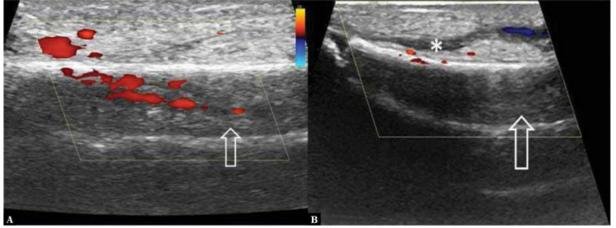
Color Doppler. A. Increased vascularization around the bone and subperiosteal collection (white arrow). B. Increased vascularity around the bone surface and deep subcutaneous tissue, and subperiosteal collection (asterisk). Source:Paliwal AK, Sahdev R, Deshwal A, Ram B. Role of ultrasound in the diagnosis of pediatric acute osteomyelitis. J Ultrason. 2021;21(84):34-40. doi: 10.15557/JoU.2021.0005. Epub 2021 Mar 8. PMID: 33791114; PMCID: PMC8008204.
